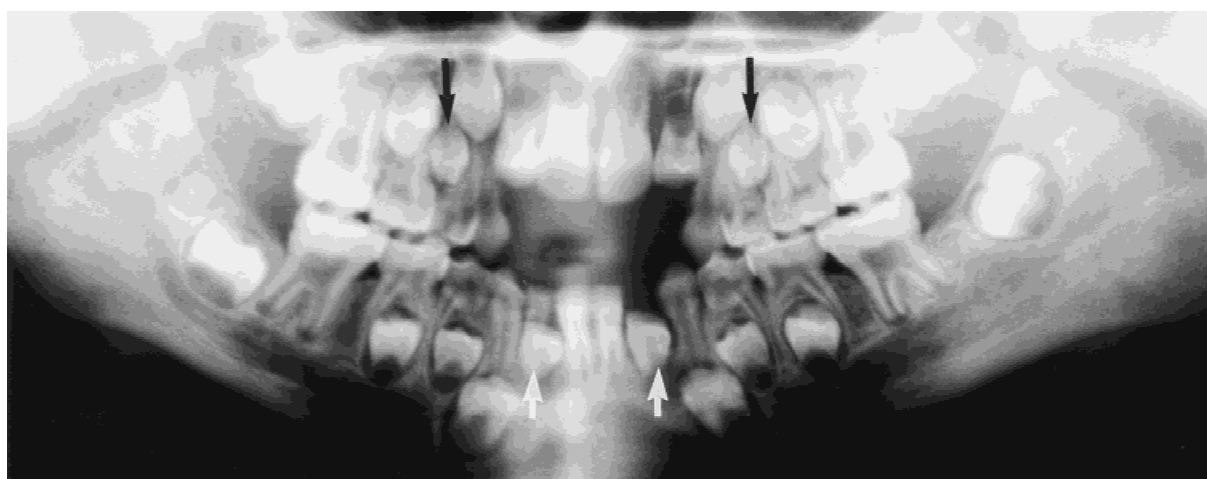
This panoramic radiograph of an 8-year-old girl diagnosed at age 1.2 years with stage D neuroblastoma shows microdontia of the maxillary first bicuspid (black arrows) and severe root stunting of mandibular permanent lateral incisors (white arrows).
